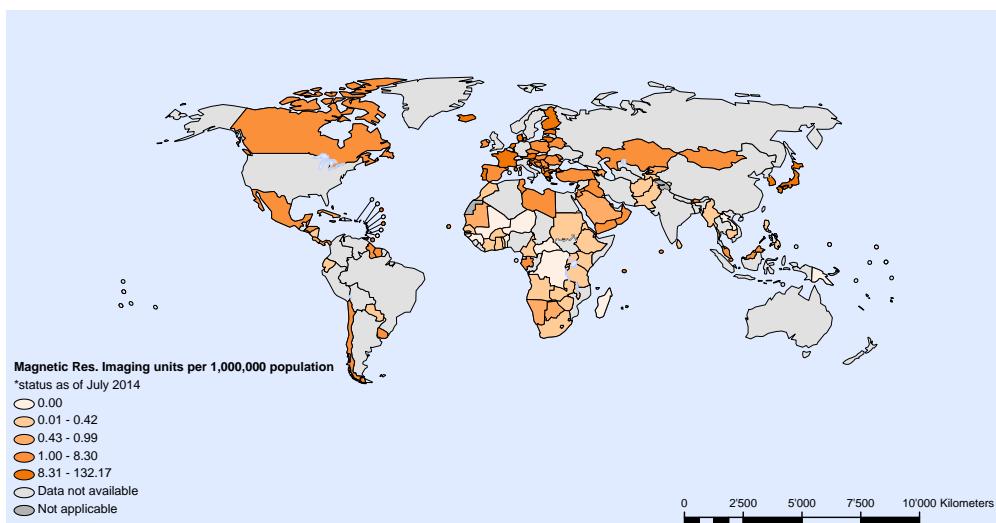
Magnetic Resonance Imaging (MRI) units per million population. 2014. Data from Global Health Observatory (14).
